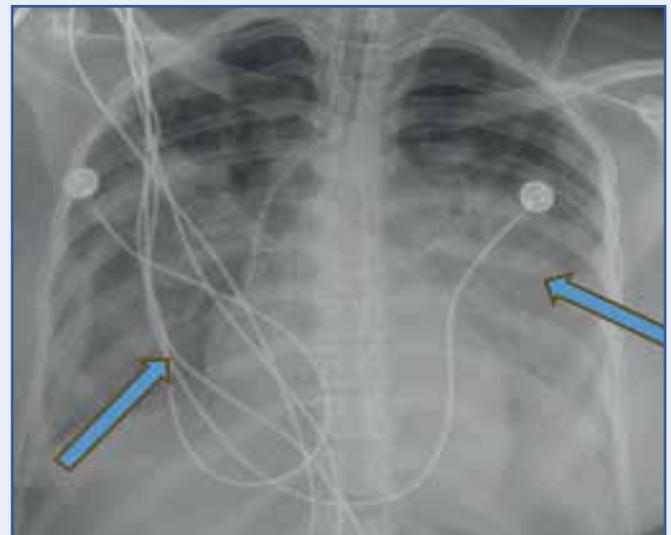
Chest Radiograph AP bilateral diffuse confluent infiltrates (blue arrows)
